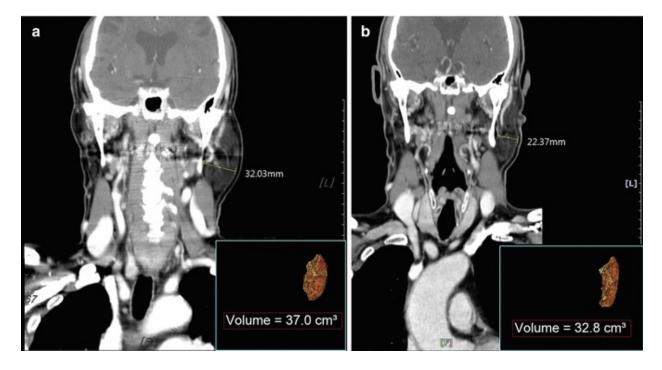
MRI showed marked reduction of parotid gland enlargement 2 months after 40 U injection of botulinum toxin (a) before and (b) 2 month after (Photo, courtesy of dermatologist Jee-Young Bae)
